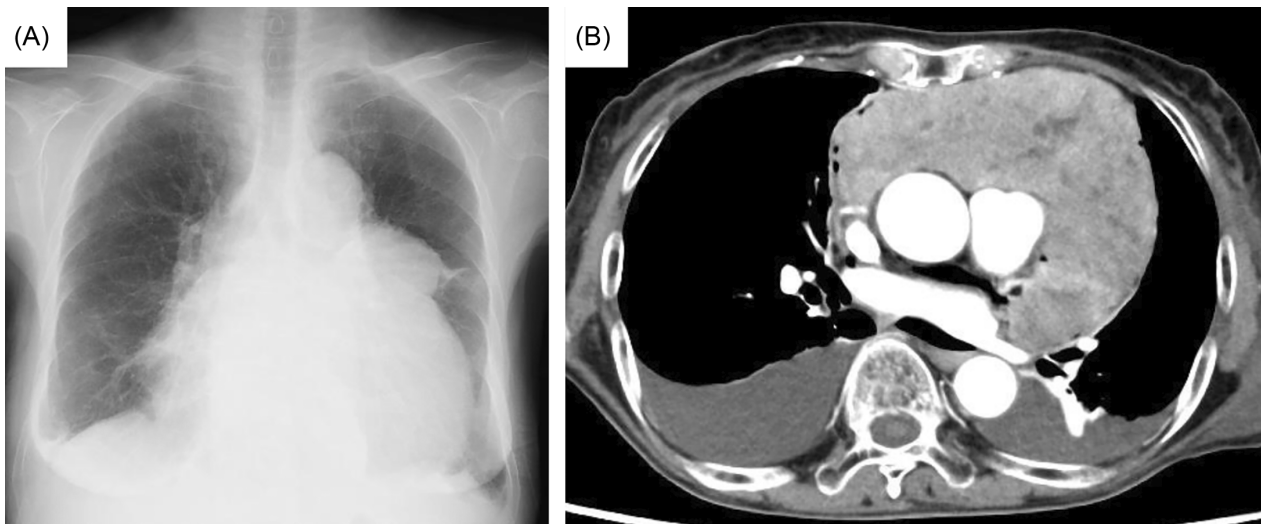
Chest x-ray and contrast-enhanced chest computed tomography (CT) findings on admission. (A) Chest x-ray showed cardiac enlargement. (B) Contrast-enhanced chest CT showed a mass in the anterior mediastinum with pericardial invasion. Pericardial effusion and bilateral pleural effusion were observed.
